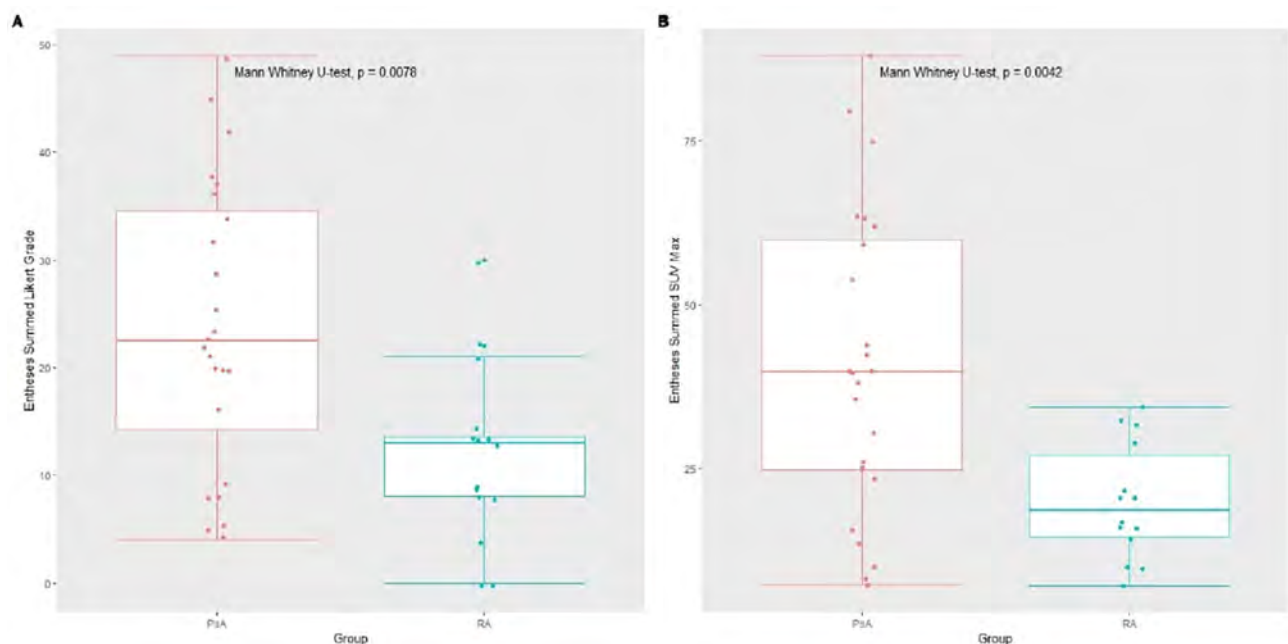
(A) Summed Likert grading of active entheses sites for PsA and RA participants; (B) Summed SUV max of active sites in PsA and RA participants.
